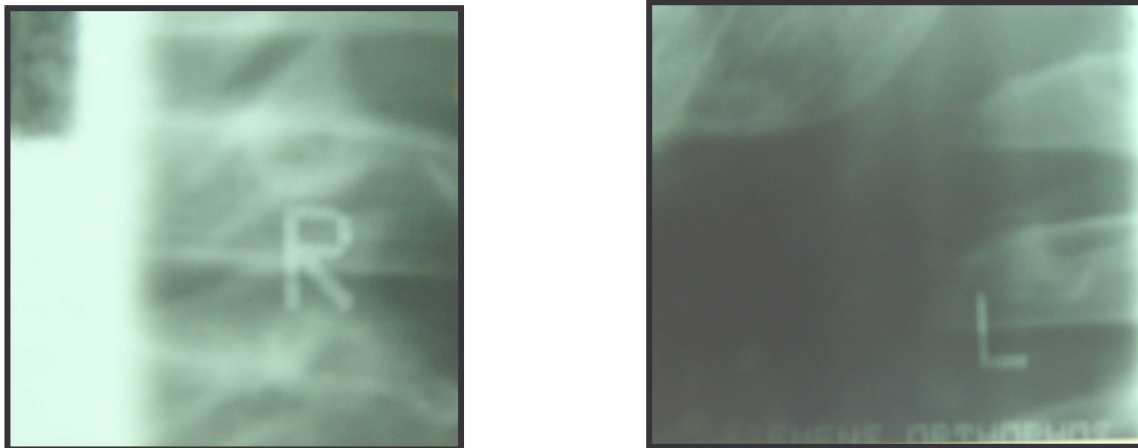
‘R’ and ‘L’ digital markers on panorex radiograph
